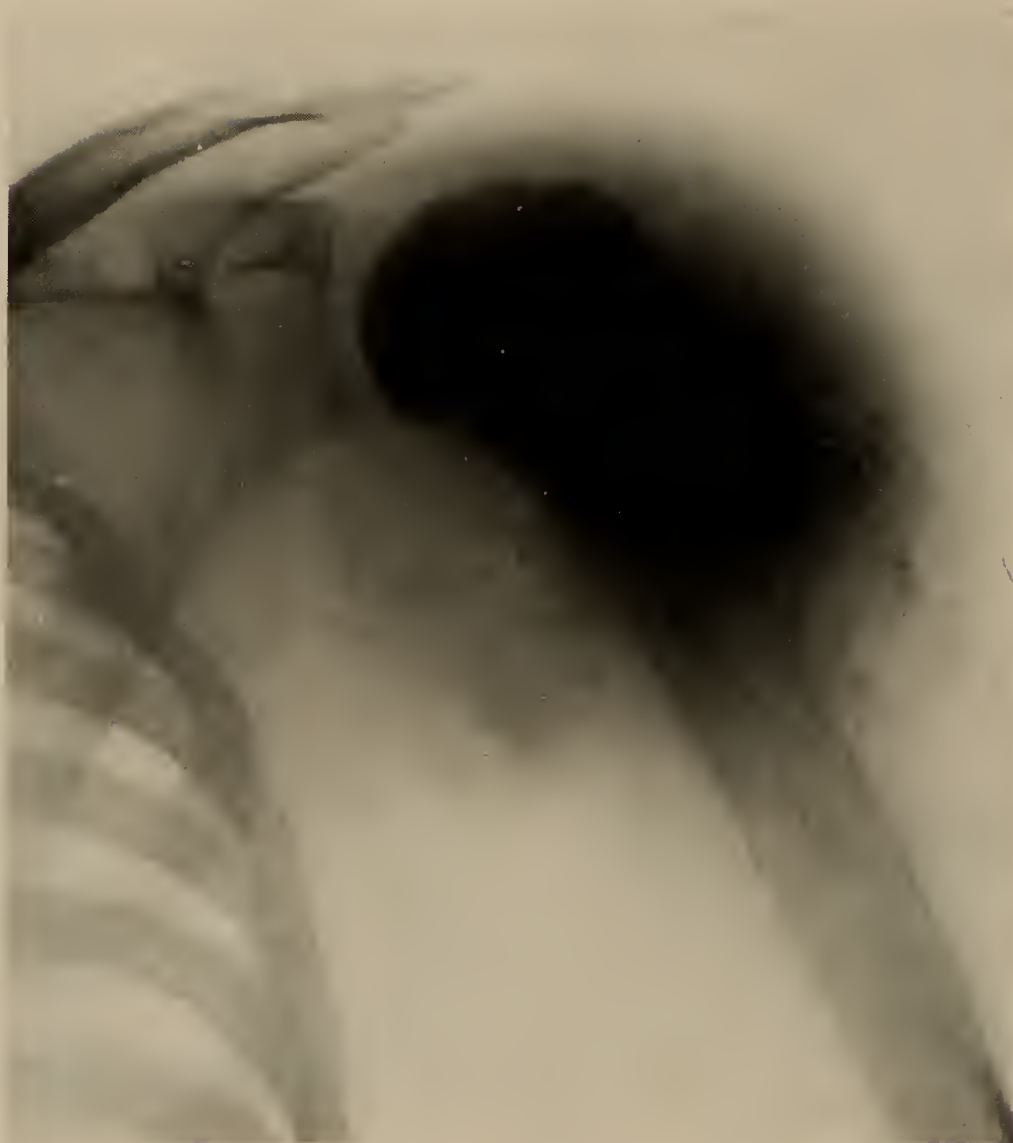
Case 371. Osteogenic sarcoma in a boy 16 years old. Typical as to location and radiological appearance. The roentgenogram was taken 2 months after the onset at which time pulmonary metastases were demonstrated. Death 7 months after the onset.
